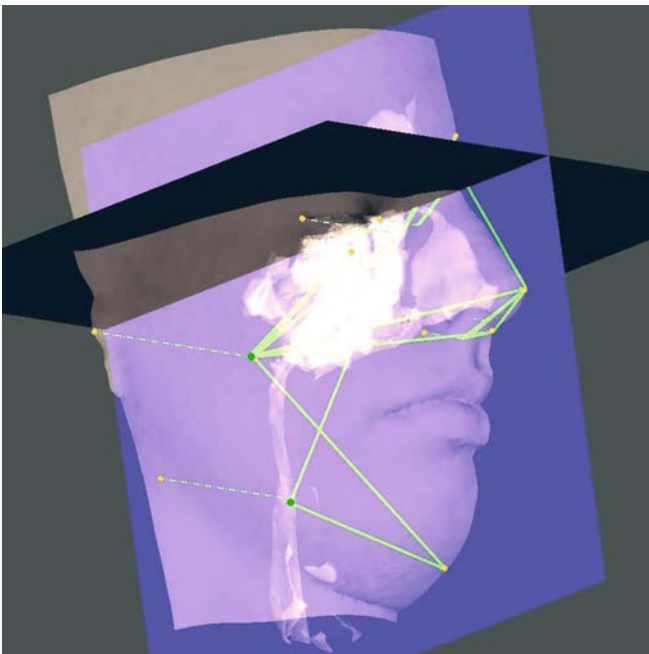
3-D cephalometric projective soft tissue depth measurements (3-D CT, transparent soft tissues, patient K.C.)
